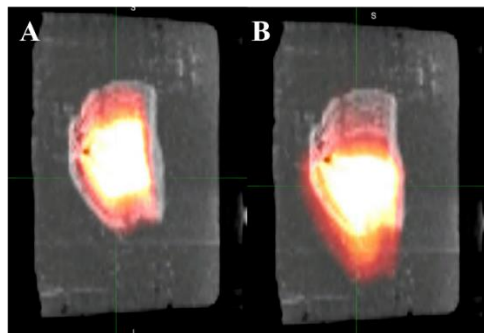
PET/4DCT images (PET/CT propagated to 4DCT MIP) of an irregular lesion fused using A) rigid image registration and B) deformable image registration. Lesion oscillated 2 cm during image acquisition.
